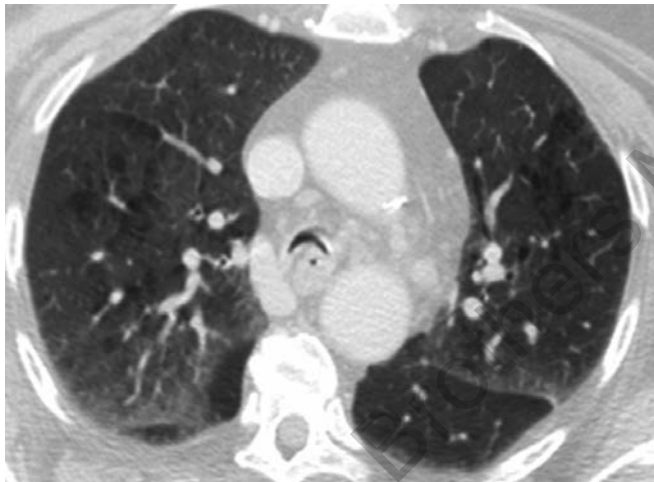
CT chest in exhalation, showing excessive airway collapse with posterior bowing resulting in tracheomalacia
